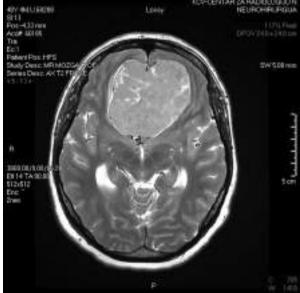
MRI – olfactory groove meningioma with optic chiasm compression
